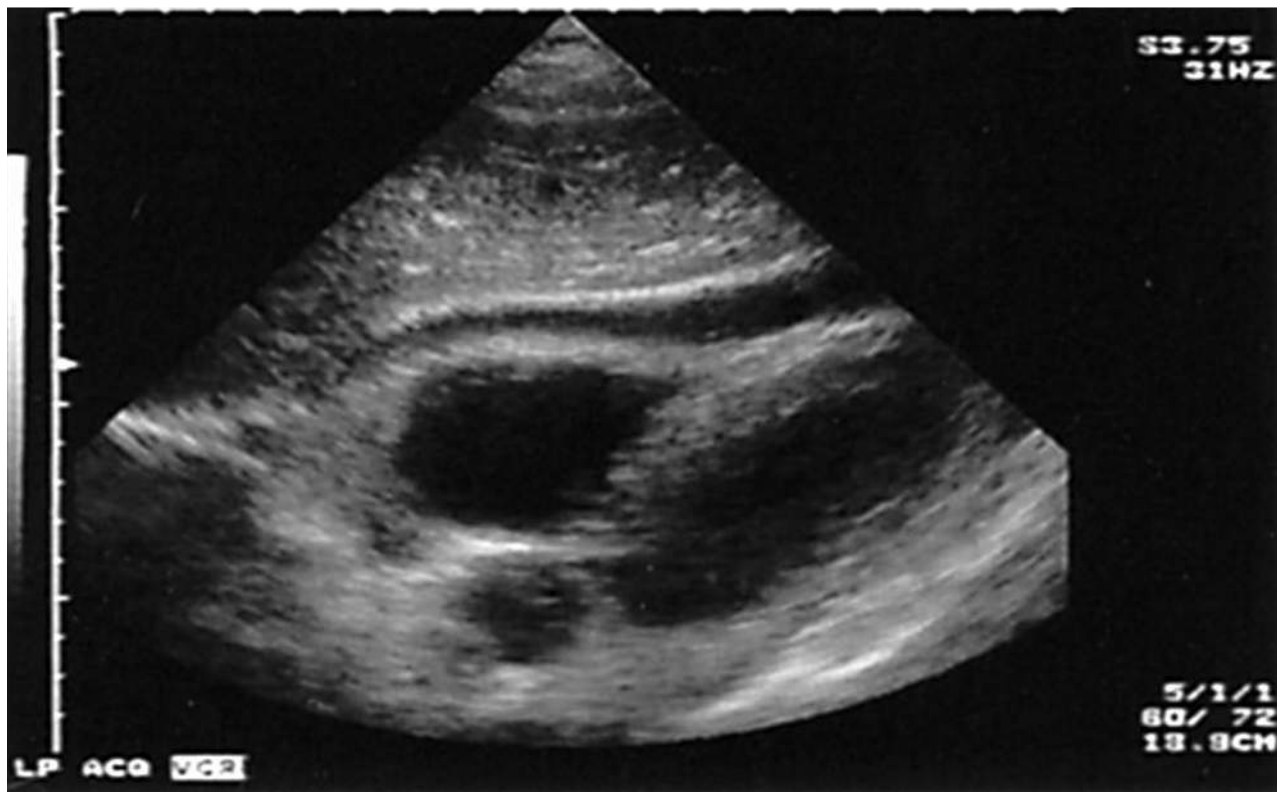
Subxiphoid pericardial ultrasound reveals a large pericardial fluid collection. (Reproduced with permission from Brunicaudi FC, Andersen DK, Billiar TR, et al: *Schwartz's Principles of Surgery*, 10th edition. New York: McGraw-Hill Inc; 2014.)
